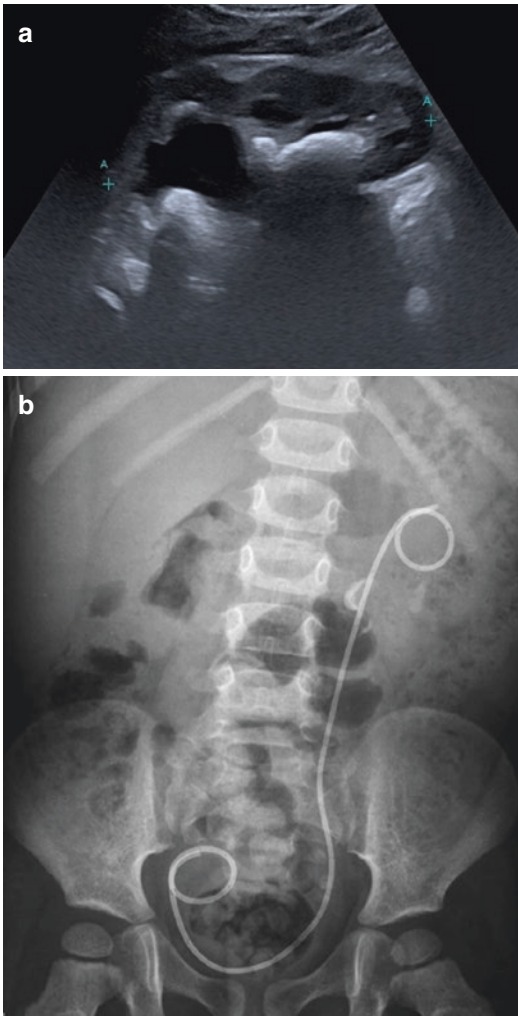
Dilatation after ESWL. (a) US Sagittal scan of the left kidney demonstrating left dilatation and fragmented lithiasis. (b) Plain radiograph of the abdomen: a JJ stent has been previously introduced; fragments of the lithiasis are visible in the left lumbar area
